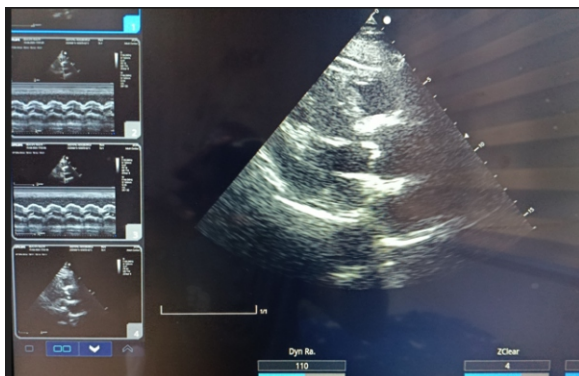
Parasternal long Axis on 2D –Echo showing echogenic aortic valve.
